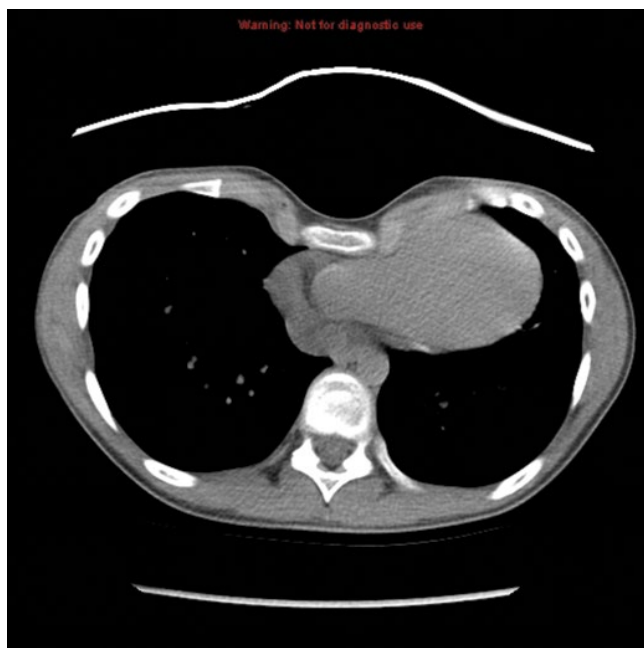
Chest CT of a 12-year-old patient with severe pectus excavatum showing cardiac compression.
